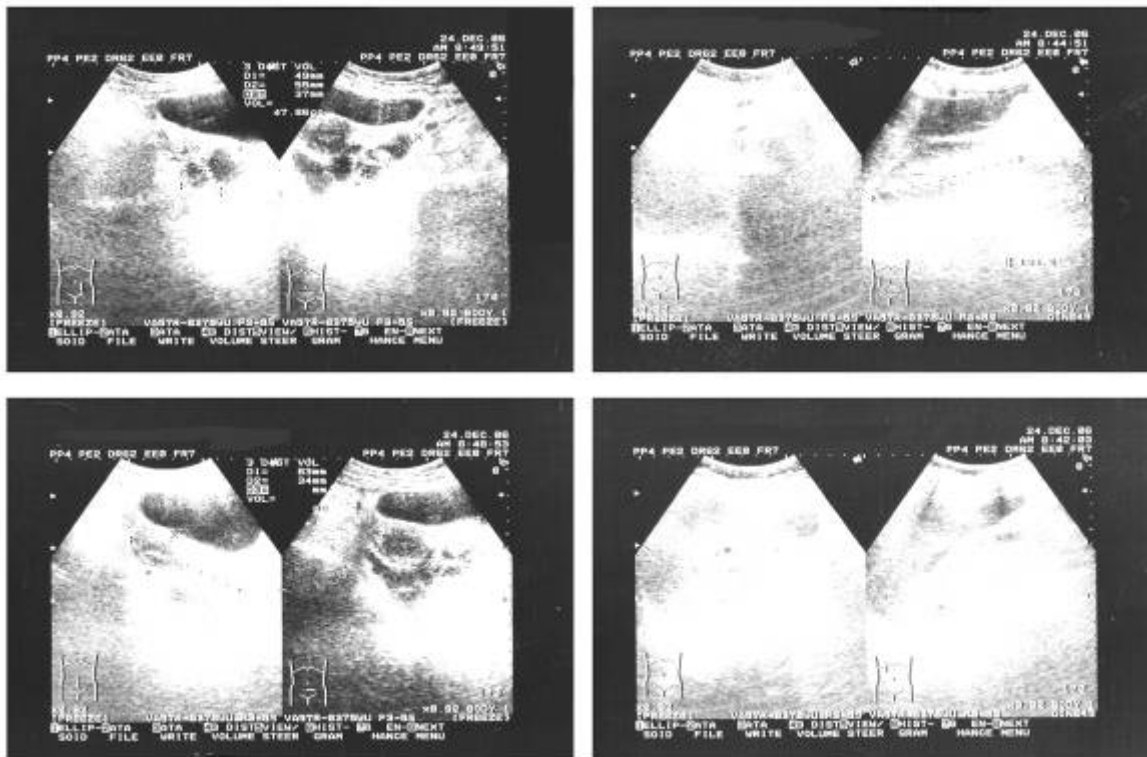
Sonographic imaging before the surgery revealed a multicystic appearance in the left ovary and absence of right ovary as a result of previous oophorectomy.
